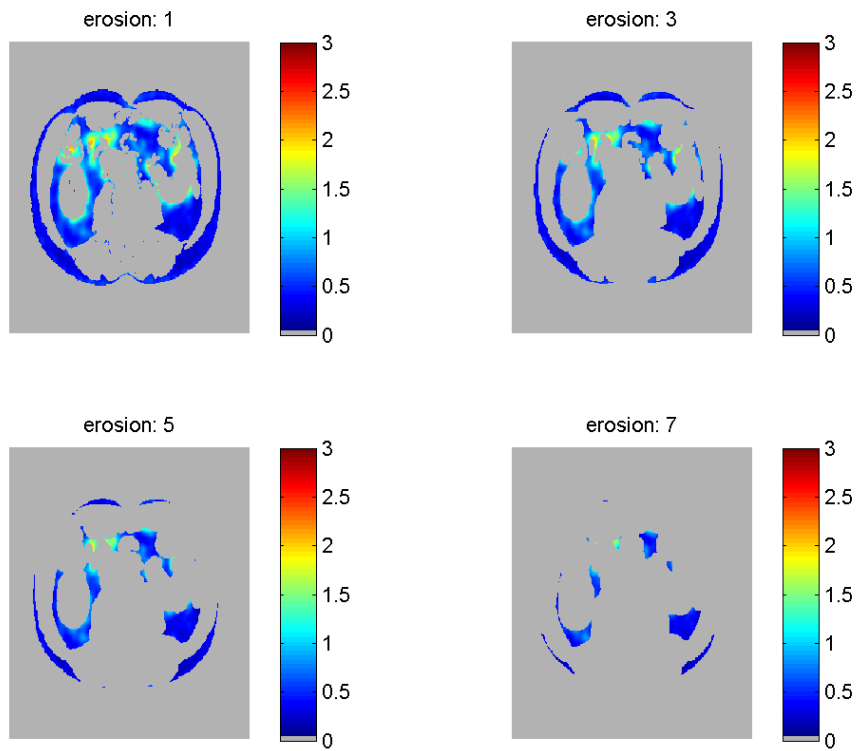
The influence of different erosions (without a SUV threshold) on the remaining VAT and SAT regions. Most spillover effects are removed for an erosion of 1 pixel. When larger erosions are used also SUV values from VAT and SAT regions are removed.
